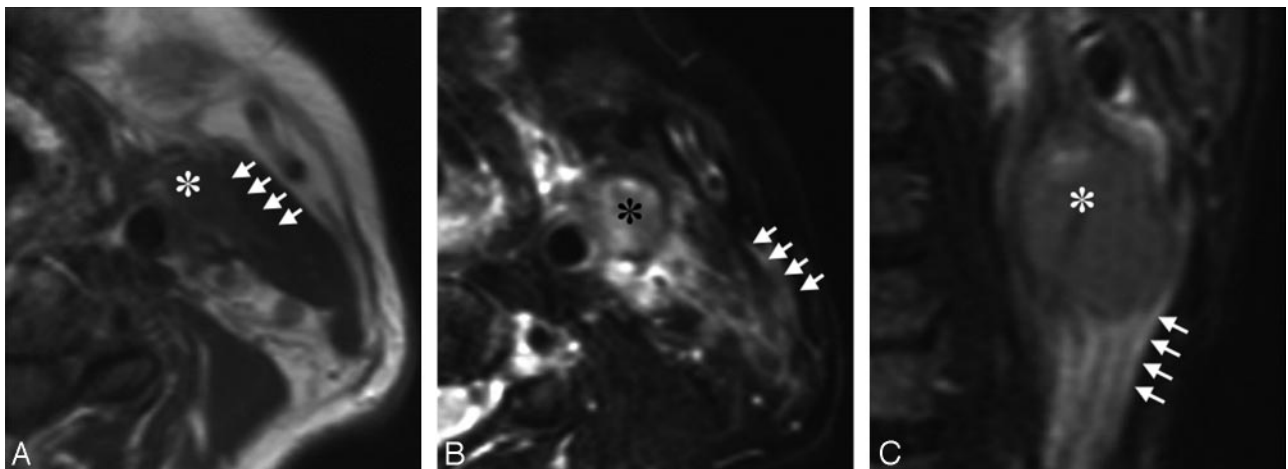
A 63-year-old man with tongue carcinoma. *A*, Axial T1-weighted (TR/TE = 500/15) image shows an ENS-positive metastatic node (asterisk) at level II. Note the vanishing border sign (arrows) with obliteration of the fat layer between the node and the neighboring sternocleidomastoid muscle. *B*, Axial fat-suppressed T2-weighted (TR/TE = 4674/80 ms) image shows the flare sign that is around and extending from the same ENS-positive metastatic node (asterisk) as in *A*. Note that high-intensity signals are present in the interstitial tissues between the sternocleidomastoid muscle and the subcutaneous fat (arrows). *C*, Coronal fat-suppressed T2-weighted (TR/TE = 4674/80 ms) image shows the flare sign (arrows) caudal to the same ENS-positive metastatic node (asterisk) as in *A* and *B*.
